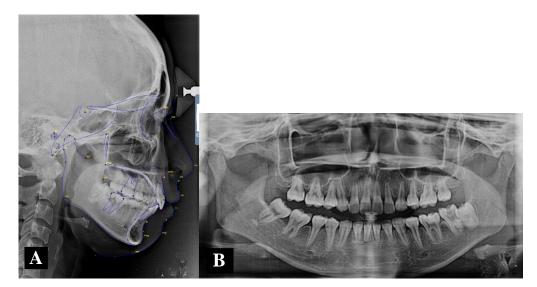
(A) Pre-treatment and (B) post-treatment lateral cephalometric and panoramic radiographs.
